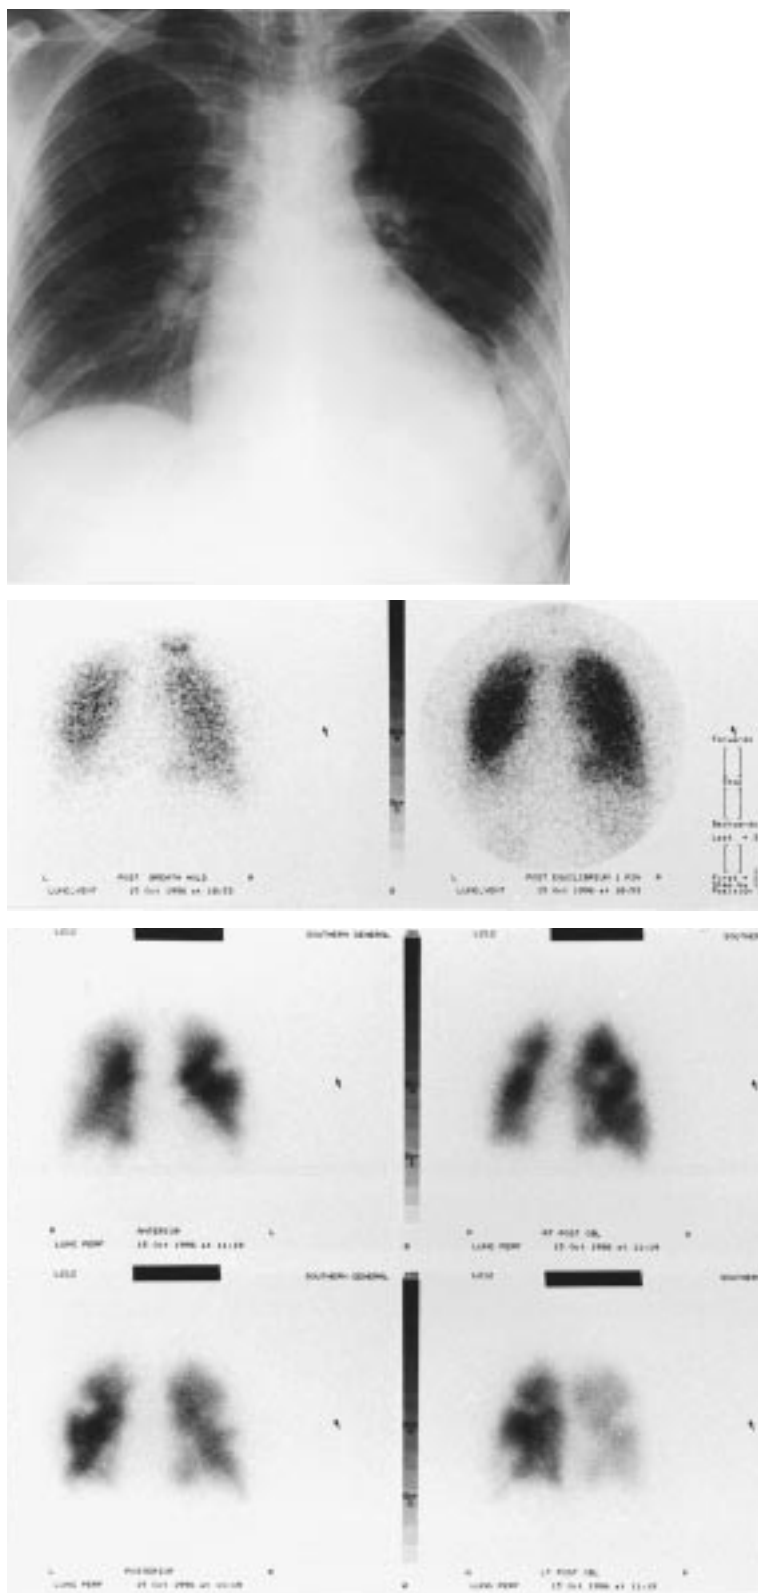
Chest radiograph showing left sided effusion (top). This is matched by ventilation defect after holding breath and after equilibrium phase in ventilation scan (middle). Four view perfusion scan shows multiple, unmatched segmental and subsegmental defects in both lungs (bottom). Thus this is high probability ventilation-perfusion lung scan by criteria of PIOPED study²
